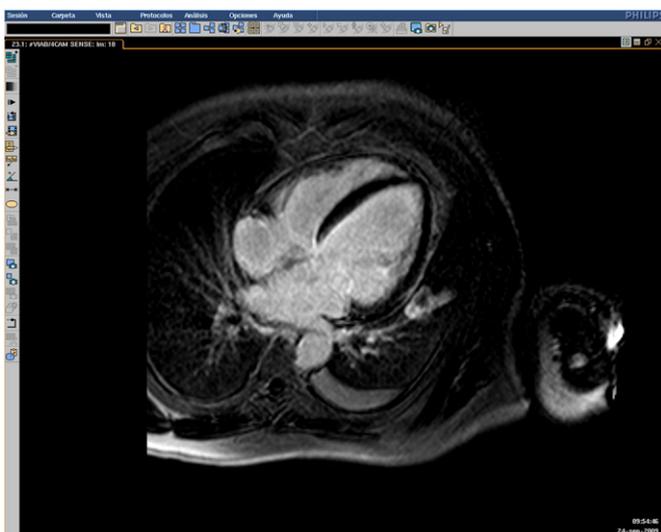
MRI, late enhancement images, 4-chamber view. No enhancement.
